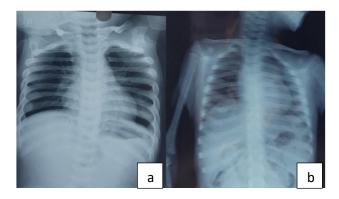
a) X-ray chest showed broad oar shaped ribs, b) X-ray chest of the unaffected twin showing normal findings.
